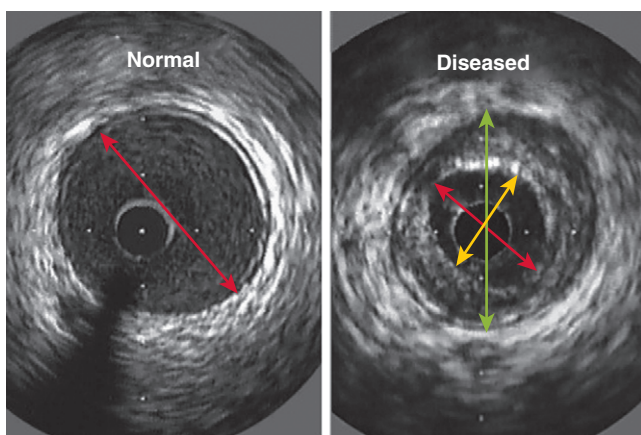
Intravascular ultrasound (IVUS) measurements for dimensions in normal (*left*) and diseased (*right*) coronary artery. Interdot distance = 1 mm. Vessel diameter computed from leading edge to leading edge adventitia (*red arrow*). Lumen diameter on right has two dimensions of an eccentric plaque (*yellow and red arrows*). Vessel dimension here is from green arrow.
